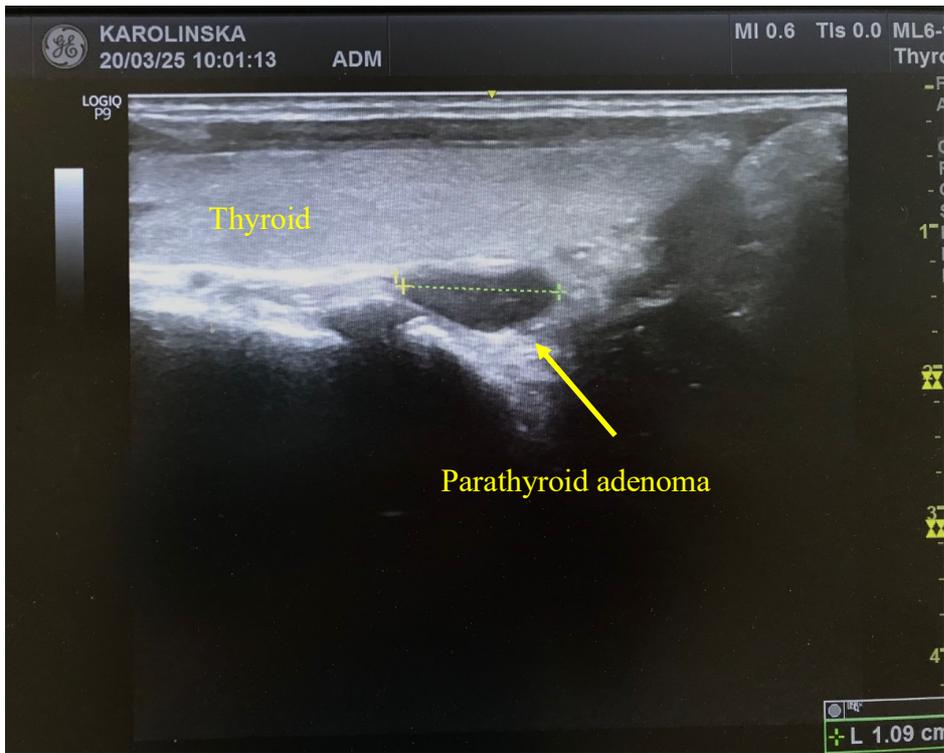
Ultrasound imaging of the inferior parathyroid adenoma.*
